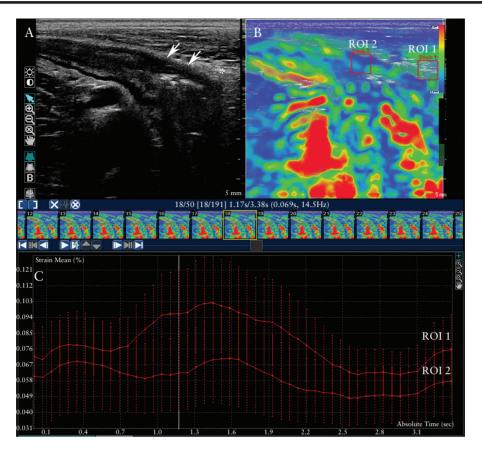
Bowel ultrasound [US] and ultrasound elasticity imaging [UEI] of a representative patient with ileal Crohn's disease before anti-tumour necrosis factor treatment. Panel A. US image showing the ileal wall [white arrows] and the surrounding mesenteric tissue [white asterisk]. Panel B. UEI colour scale imaging with the selection of regions of interest in the mesenteric tissue [ROI 1] and in the bowel wall [ROI 2] to calculate tissue strains. Panel C. Quantitative strain values of ROI 1 [mesenteric tissue] and ROI 2 [ileal wall] plotted over time.
